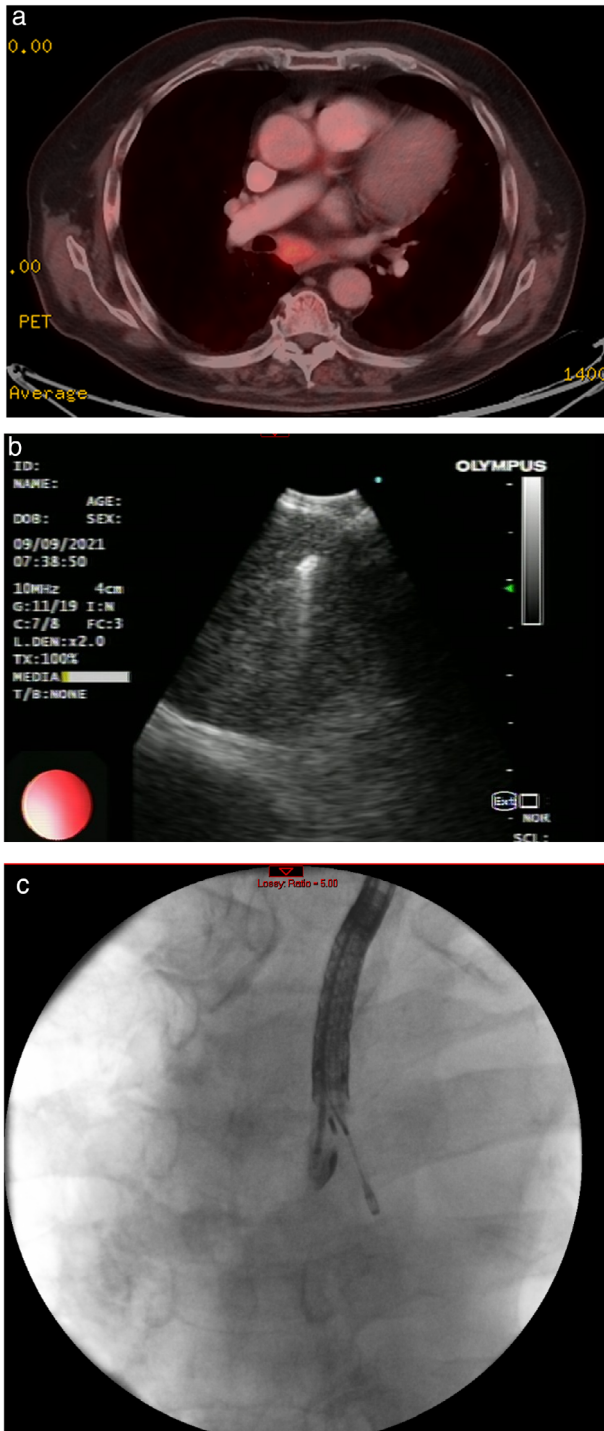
Sixty-year-old male with abnormal chest findings on imaging. (a) Positron emission tomography-computed tomography scan with fluorodeoxyglucose avid subcarinal lymph node. (b) Endobronchial sonography of 1.1 mm cryoprobe inside the subcarinal lymph node. (c) Fluoroscopy image of EBUS with cryoprobe in subcarinal lymph node
